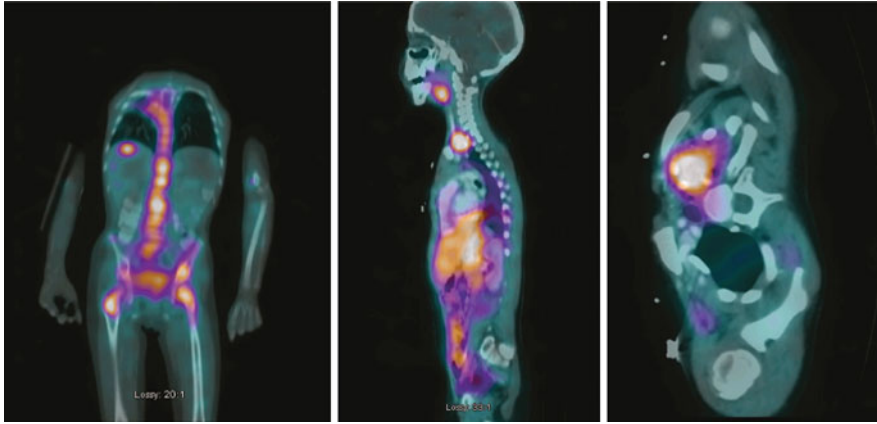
The paediatric cancer neuroblastoma. Neuroblastoma (NB) is a childhood tumor that arises within the peripheral nervous system. Despite aggressive therapy, the survival rate of relapsed NB patients remains extremely low, and innovative therapeutic approaches are urgently needed. The MYCN-regulated ornithine decarboxylase (ODC) is a rate-limiting enzyme of polyamine biosynthesis. Since polyamine homeostasis is deregulated in NB, ODC provides a potential drug target. The I-123 metaiodobenzylguanidine (MIBG) – single photon emission computed tomography (SPECT) images show
